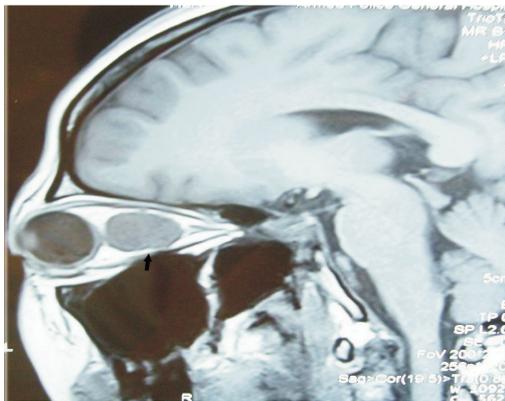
Distorted optic nerve (black arrow) revealed by sagittal MRI in case 2 with severe adhesion
